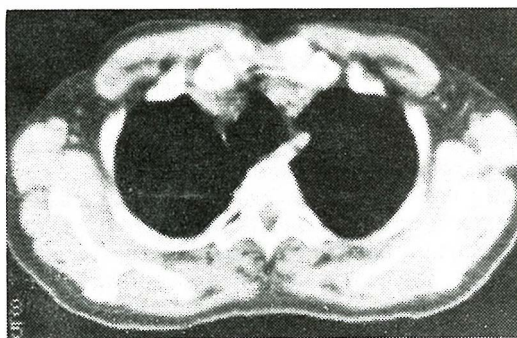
CT slice: marked dilatation and deformity of trachea.
